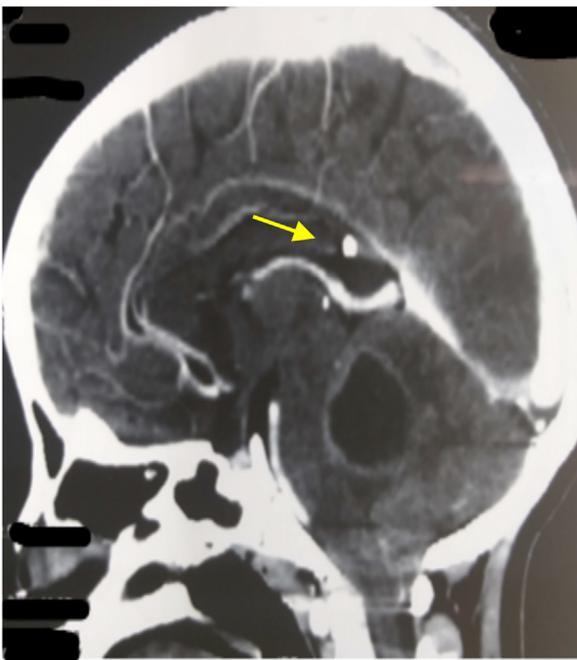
Axial cut brain CT showing recurrence of the abscess and the shunt in place (yellow arrow).
